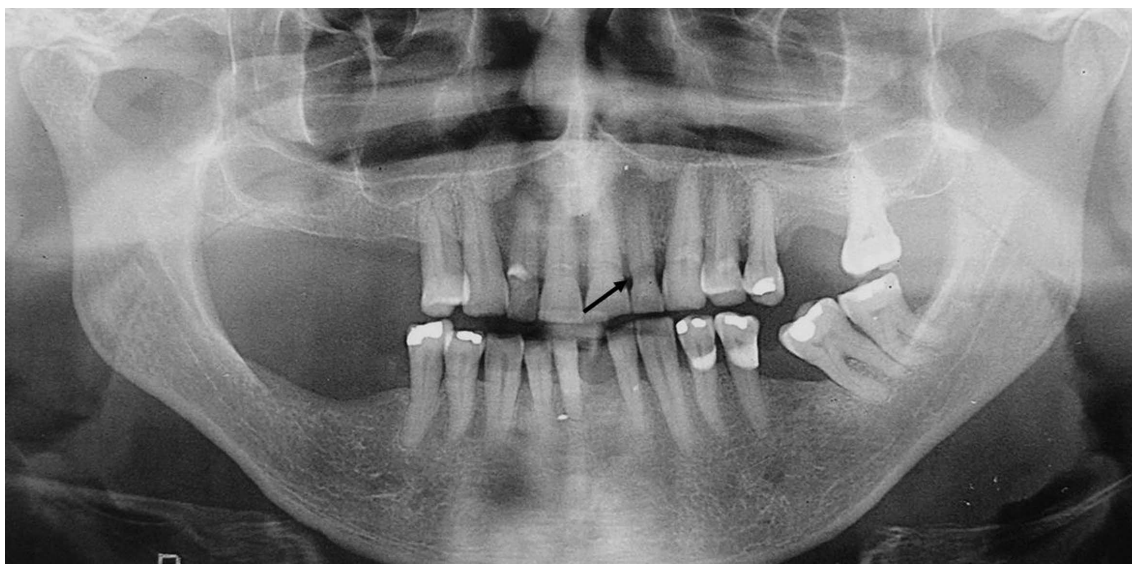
Root surface carie lesion (arrow) in an anterior tooth panoramic radiographic examination.
